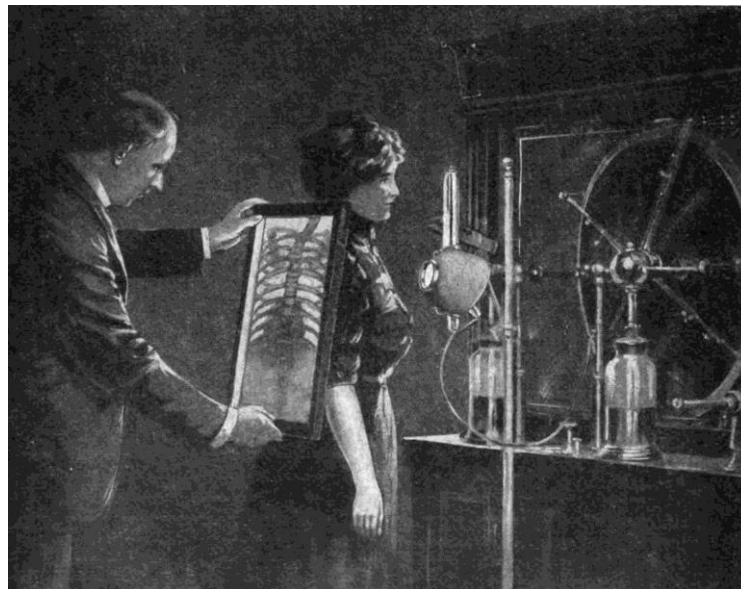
Chest fluoroscopic X-ray using a hand-held fluorescent screen, 1909. No radiation protection is used as the dangers of X-rays were not yet recognized [25]
